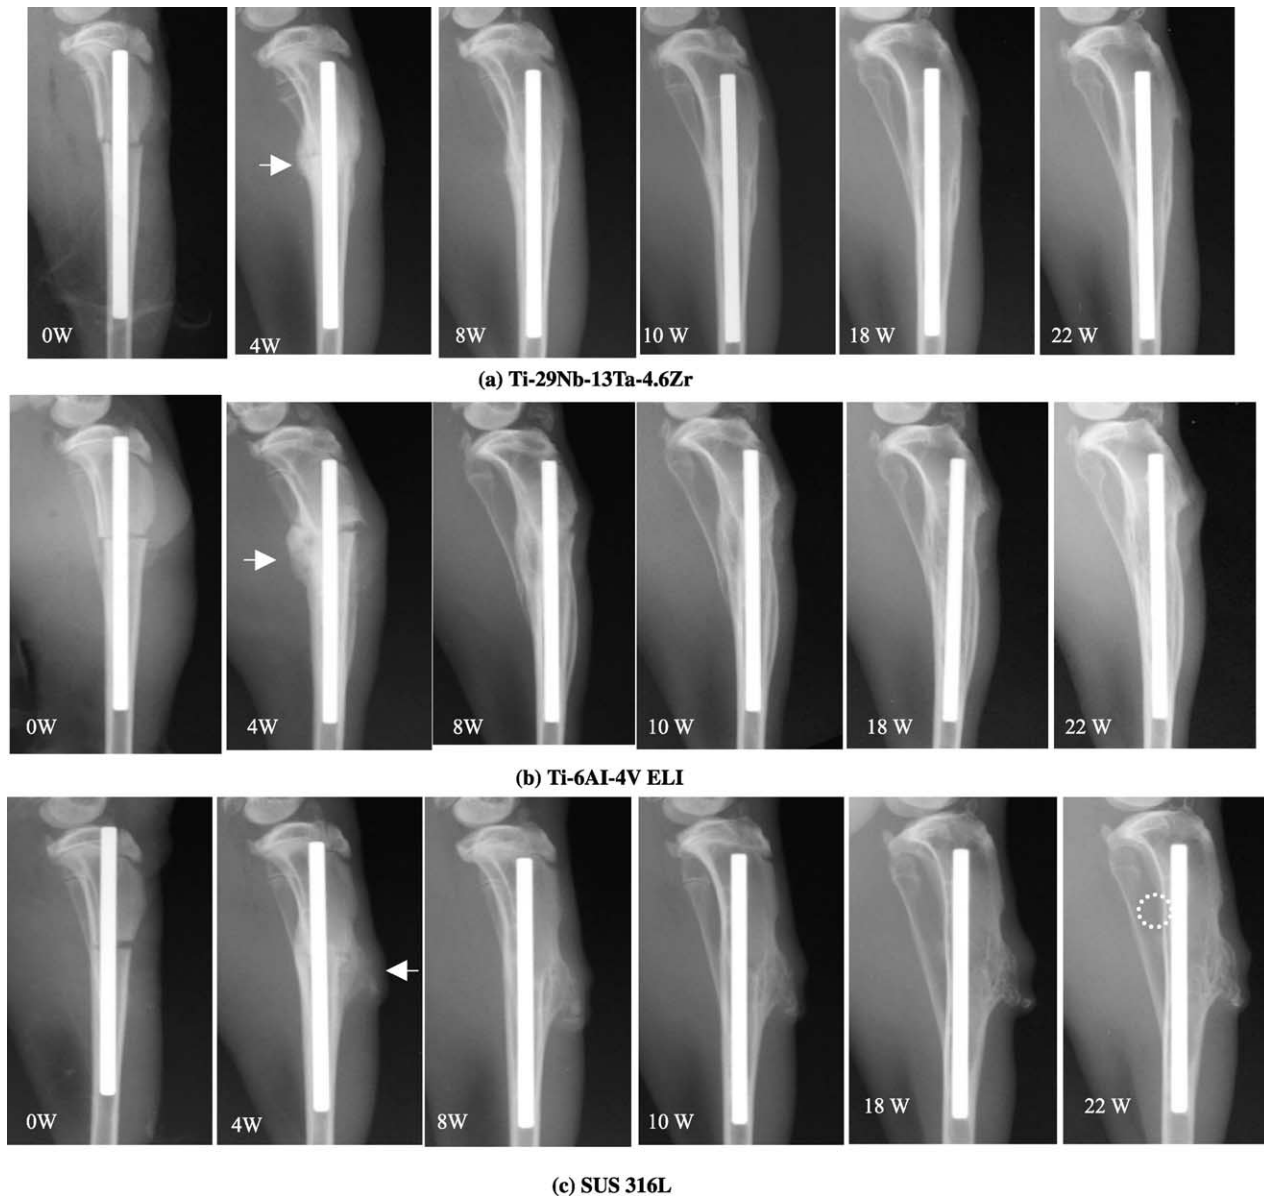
Healing process of bone fracture from 0 to 22 weeks after surgery observed by X-ray. Arrow and dotted round mark show callus formation and atrophic change, respectively.
